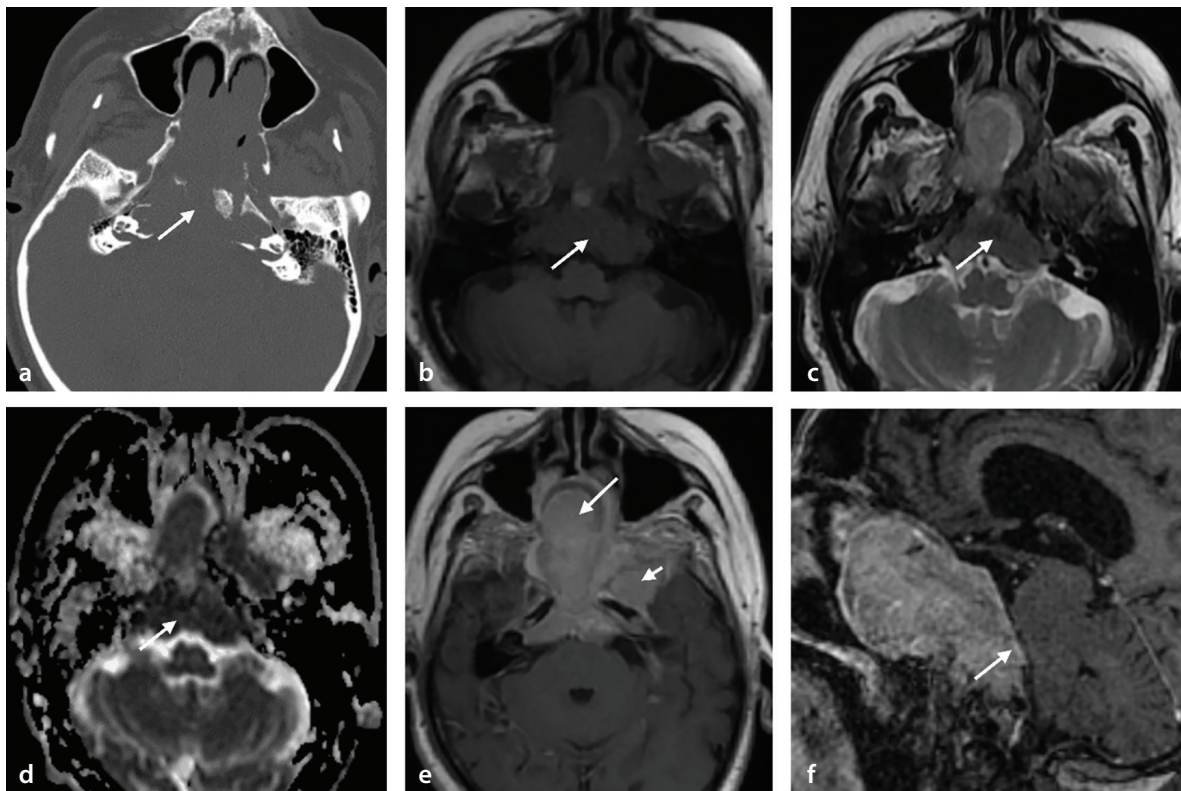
Radiological images of a 74-year-old male patient presenting with nausea, vomiting, and left eyelid ptosis, diagnosed with atypical meningioma (World Health Organization grade 2) invading the clivus. The computed tomography scan (a) reveals a lytic expansile lesion, whereas the lesion appears isointense on T1-weighted (b) and T2-weighted (c) images, with low apparent diffusion coefficient (ADC) values on the ADC map (d). Post-contrast images (e, f) demonstrate homogeneous contrast enhancement of the expansile clival lesion (arrow). The lesion invades the right sphenoid sinus, extends bilaterally into the parasellar region, reaches the masticator space on the left, and posteriorly extends into the prepontine cistern.
